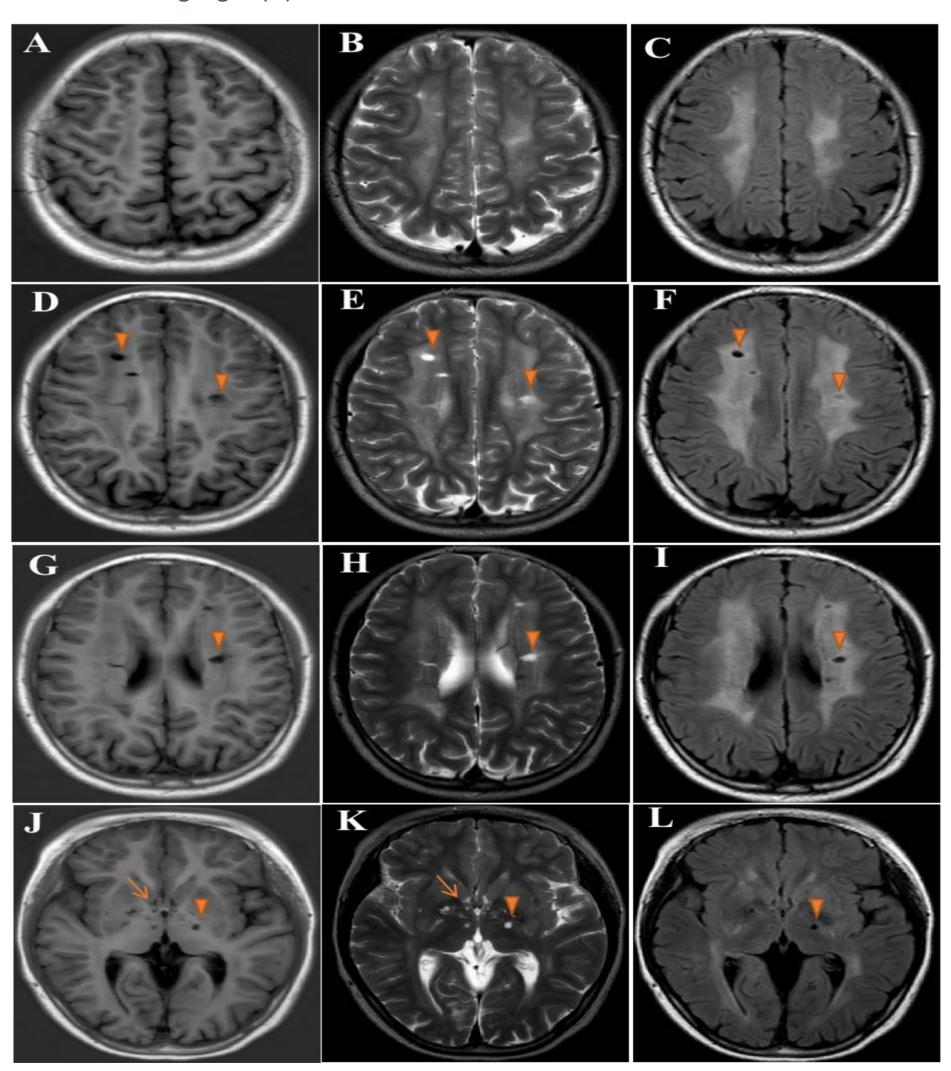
The brain MRI of the patient at 12 years old showed diffuse periventricular leukoencephalopathy (A-I), lacunes (arrowheads) in bilateral centrum semiovale (D-F), periventricles (G-I) and bilateral basal ganglia (J-L), dilated perivascular spaces (arrows) in bilateral ganglia(J-K).
